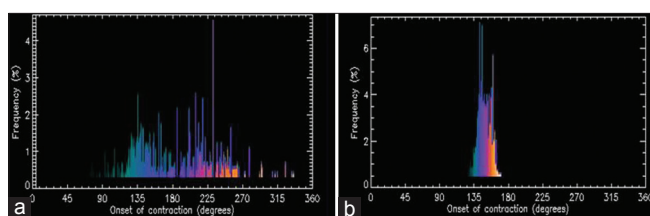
Gated-SPECT. Synchronism, (a) Acute onset. (b) Two months later
